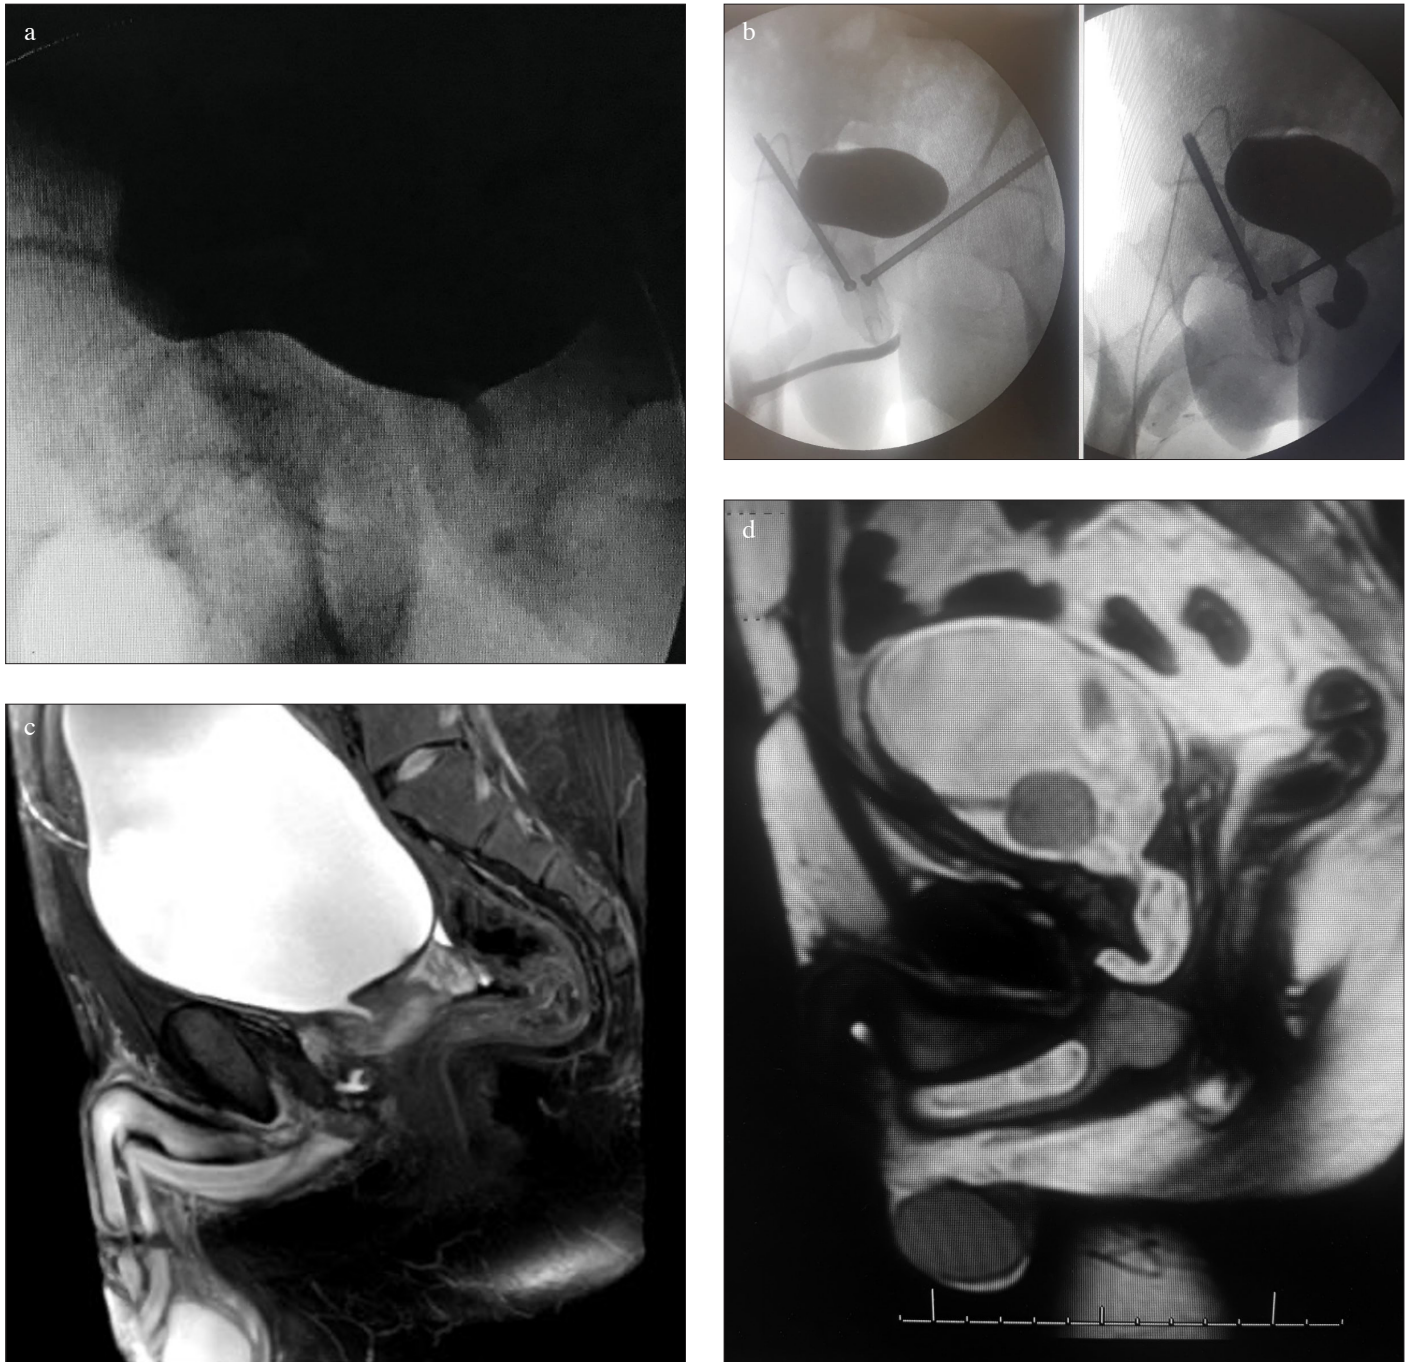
a-d. (a) Two-dimensional voiding cystourethrogram (VCUG) image. (b) Voiding cystourethrogram (VCUG) shows curved posterior urethra but does not predict the direction of displacement. (c) Magnetic resonance imaging (MRI) with our protocol showing posterior displacement of prostate. (d) Three-dimensional magnetic resonance imaging (MRI) showing that the posterior urethra is displaced anteriorly
